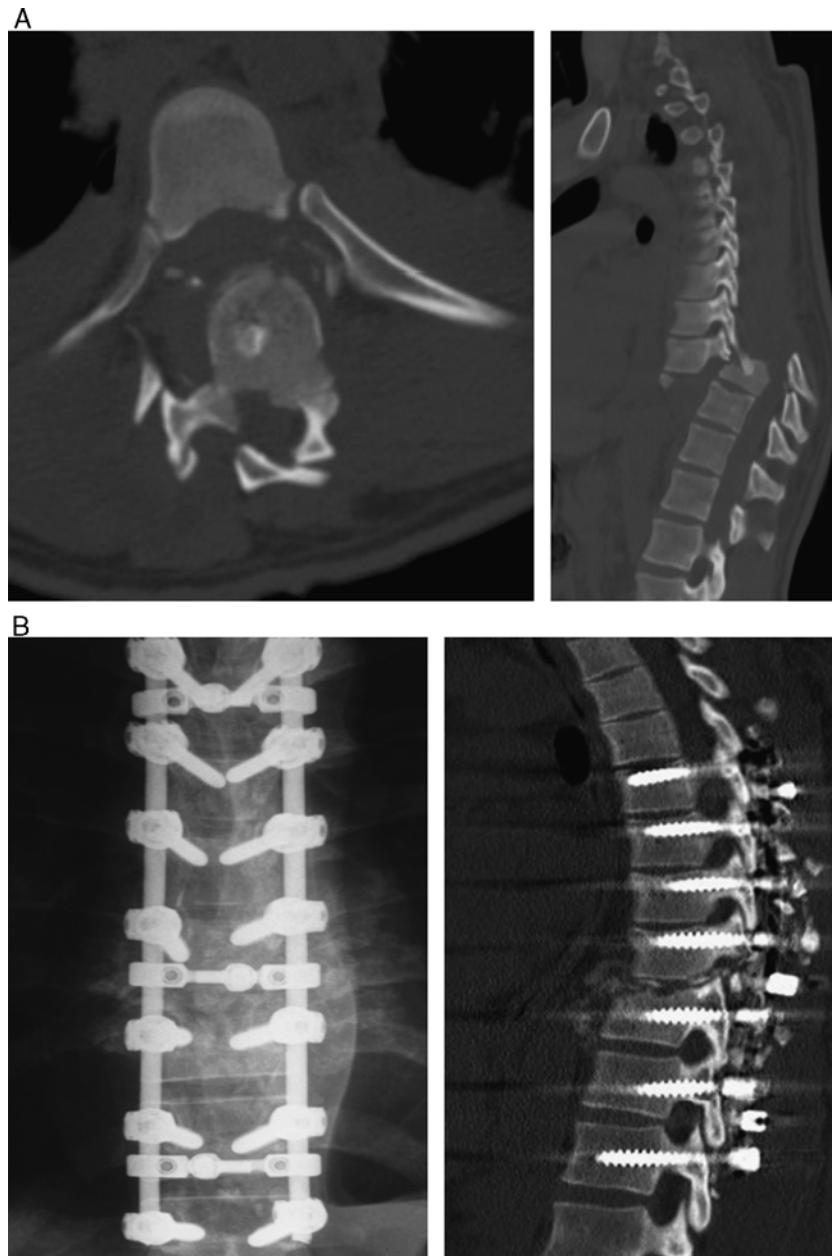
A, A 32-year-old man who presented with T10 fracture and T9-T10 dislocation after jumping from a fourth floor. Preoperative CT scan showing the fracture-dislocation and severe displacement. B, T10 vertebrectomy and spine shortening were done 28 days after trauma because of respiratory problems. Immediate postoperative radiography and CT scan showing good segmental alignment and the close apposition of the endplate of T9 on the endplate of T11. CT indicates computed tomography.
